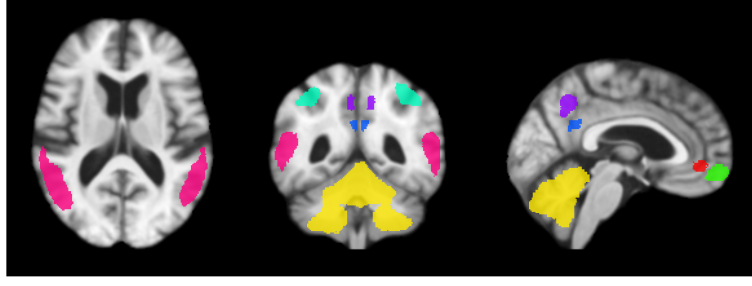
The target and reference regions used to calculate the mean SUVR. The six cortical regions shown to have prominent uptake of $A\beta$ in AD versus control are: medial orbital frontal (green), parietal (cyan), temporal (magenta), precuneus (purple), anterior cingulate (red) and posterior cingulate (blue). The reference region is the cerebellum (yellow).
